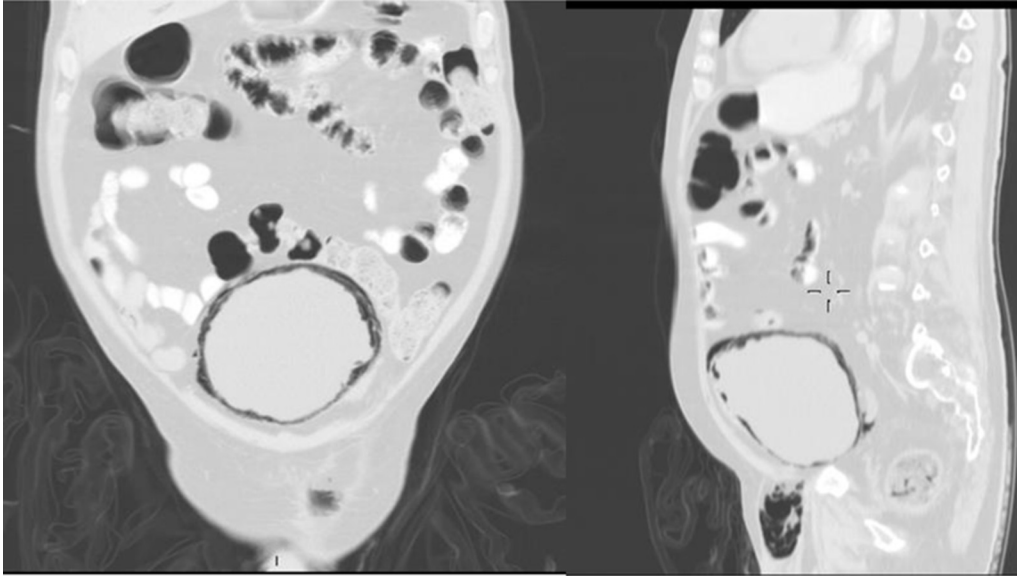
CT scan of the abdomen in coronal and sagittal view (lung window): diffuse air bubbles within the bladder wall.
